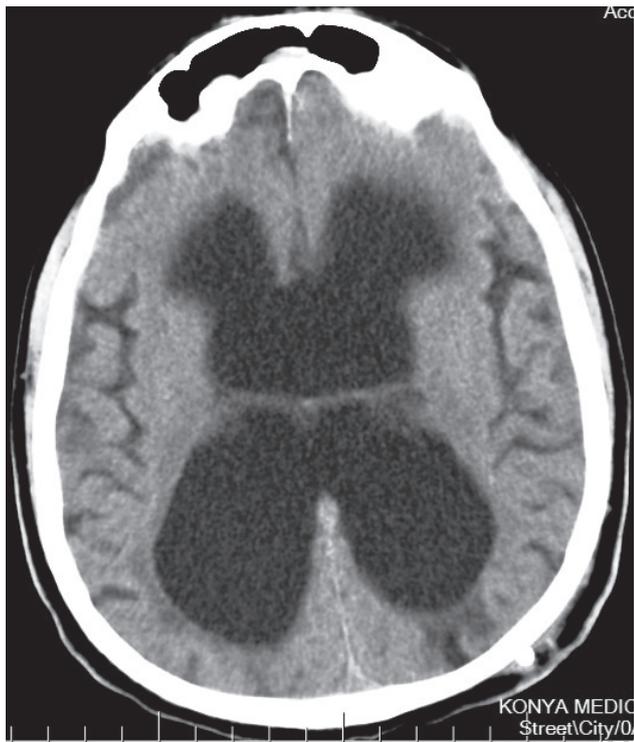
Postoperative cranial axial CT scan revealing a moderate decrease in ventricle sizes and a gross-total excision of arachnoid cyst.
